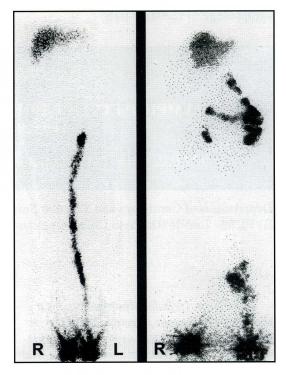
Typical lymphoscintigrams of 2 different patients demonstrating impaired radiotracer transport in the right leg after repeated episodes of "erysipelas".
